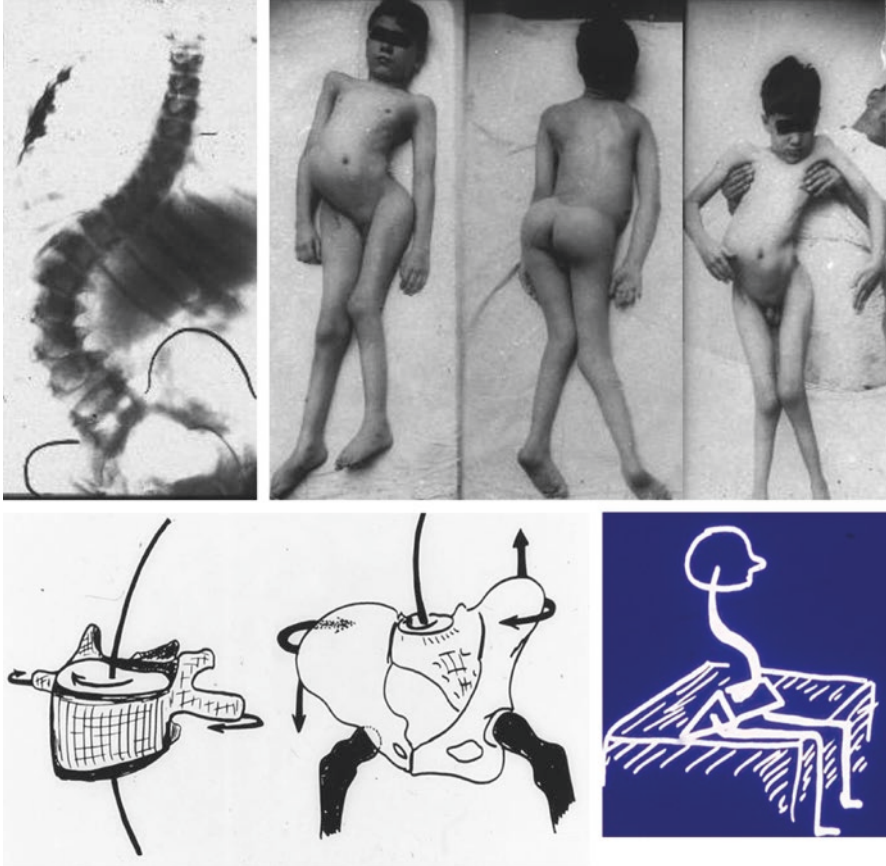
Scoliosis and pelvic obliquity. The entire pelvis is considered as one unique vertebra, displaced in the three dimensions of the space. The clinical picture of such a patient is very demonstrative of such definition, but not so well approached by the X-ray projection
